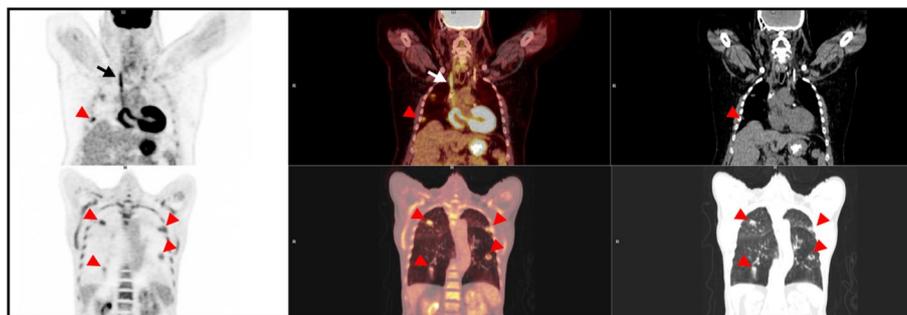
Coronal view of [18 F]FDG-PET/CT where abnormal uptake was found in the tract of the already extracted central catheter (arrow) and in bilateral septic pulmonary embolism (arrowhead)
